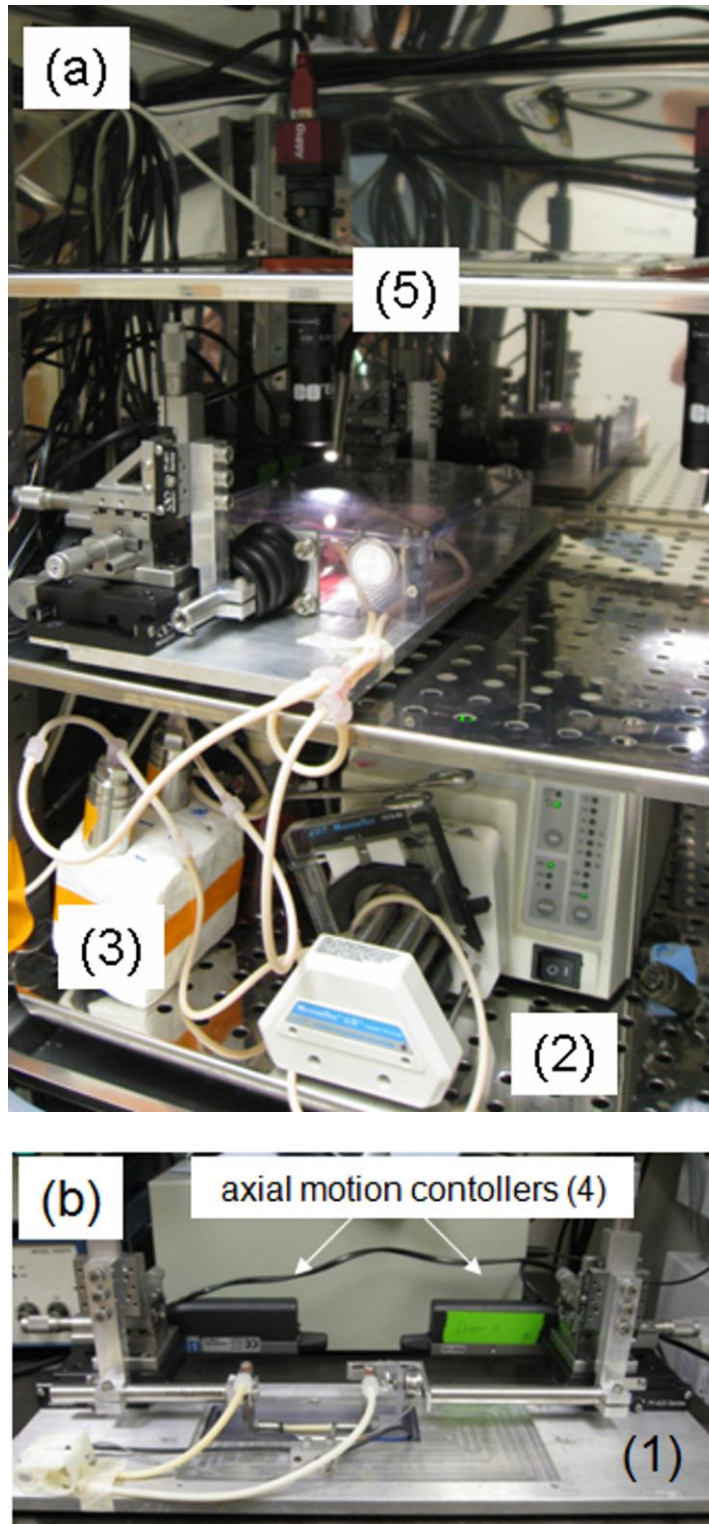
Bioreactor/biomechanical testing device for TEBVs with subsystems as noted in text. Fully assembled system shown in incubator (a). Image of culture chamber showing axial motion controllers as well as mounted BVS (b). Detailed image of BVS showing points of attachment to cannula, ultrasound transducer, and load cell (c).
